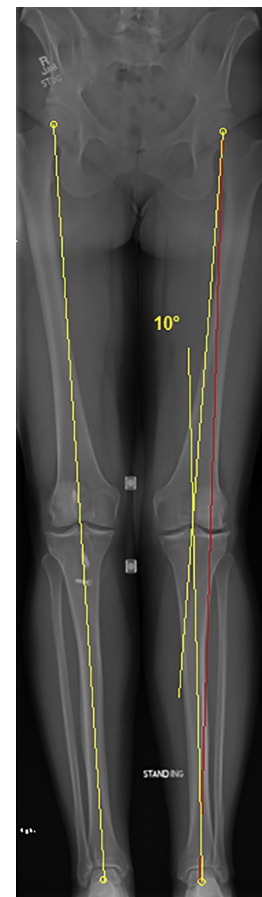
Preoperative planning of the osteotomy correction. A standing hip to ankle radiograph is used to calculate the mechanical axis of the lower limb and determine the desired degree of correction. A line is drawn from the center of the femoral head to the center of the intercondylar notch, and another line is drawn from the center of the intercondylar notch to the center of the ankle. The angle formed by the intersection of these 2 lines is the degree of correction needed to restore neutral mechanical alignment.
